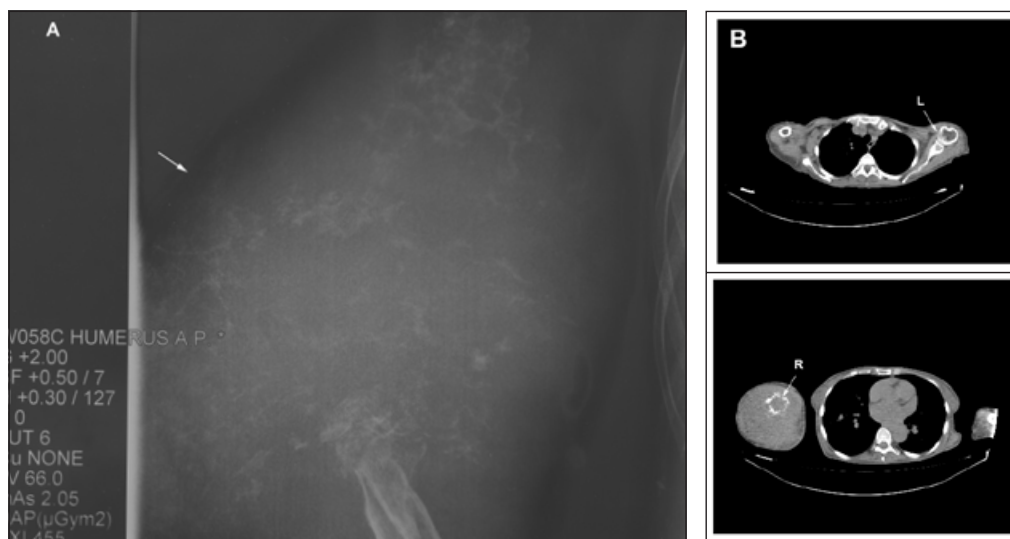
A: X-rays of the right humerus of the patient revealed the virtual absence of the lower half of the diaphysis, suggesting a massive osteolysis of unknown etiology. B: Further investigation of the patient by CT verified the massive osteolysis of the lower section of the right humerus, while another asymptomatic lytic lesion was also seen in the contralateral humerus (the sections correspond to different levels of each arm). The accompanying edema of the left arm is clearly seen, but no other bone or parenchymal lesion was observed.
